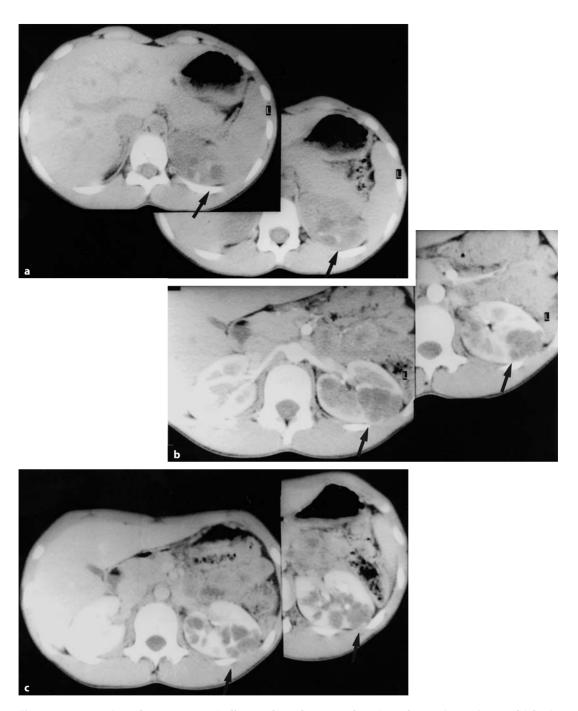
Cystic nephroma: traumatically complicated segmental cystic nephroma (*arrows*) on multiphasic contrast-enhanced CT
